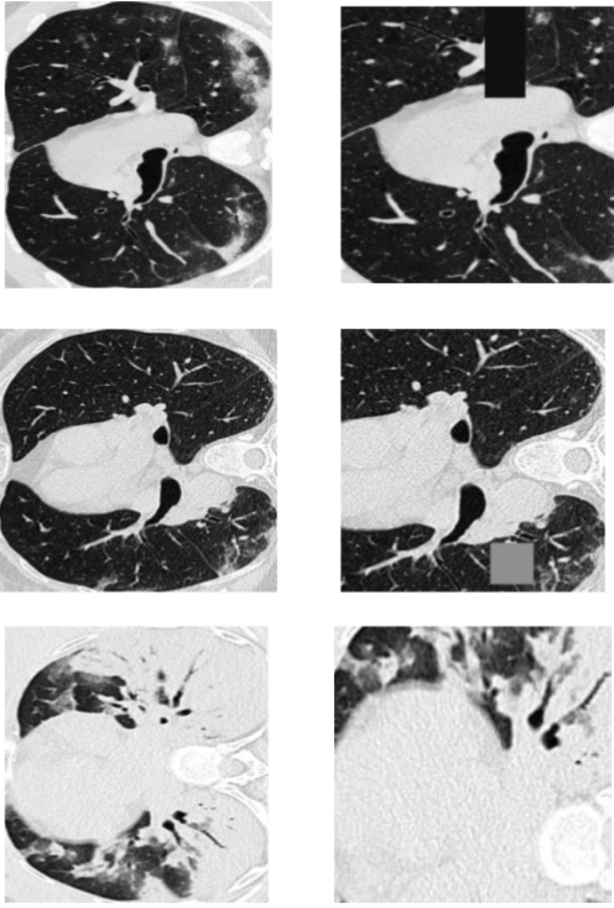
Example CT lung images of our data augmentation. The left column is the original CT lung images while the right column is the augmented CT lung images. The first row of the CT lung images involves random cropping and random cutout. The second row of the CT lung images involves random cropping and random cutout. The third row of the CT lung images involves random cropping and vertical flipping. We can see the random cutout involves patching the image with colors of the same value of rgb. For instance, if the value of r is 10, then the value of g and b are also 10. If the value of r is 50, then the value of g and b are also 50.
